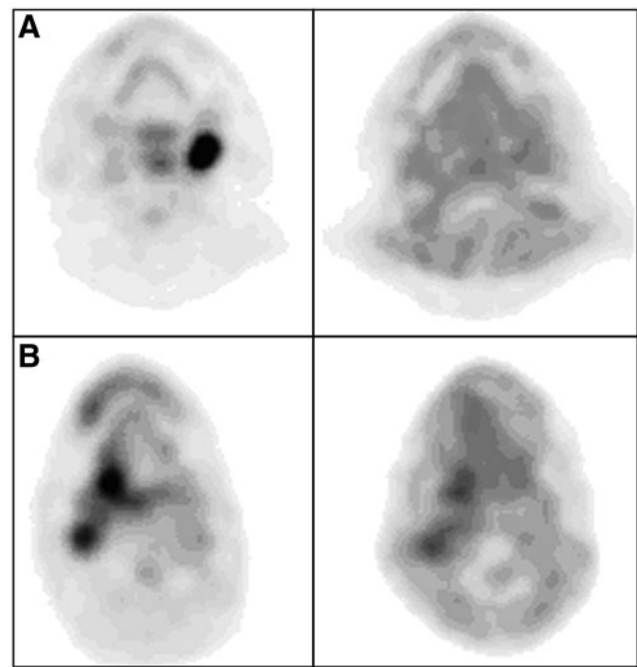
From left to right: transaxial ^{18}F -FDG PET; transaxial ^{18}F -FMISO PET of head and neck tumors. (A) normoxic ($\text{HP}_{2.5} = 13.0\%$; ^{18}F -FDG $\text{SUV}_{\text{mean}} = 14.80$; ^{18}F -FMISO $\text{T/M} = 1.31$). (B) hypoxic ($\text{HP}_{2.5} = 37.7\%$; ^{18}F -FDG $\text{SUV}_{\text{mean}} = 8.00$; ^{18}F -FMISO $\text{T/M} = 1.60$). Reprinted by permission from Gagel *et al.* (95). ^{18}F -FDG, ^{18}F -fluorodeoxyglucose; $\text{HP}_{2.5}$, hypoxic fraction below 2.5 mmHg; SUV, standard uptake value; T/M, tumor to muscle ratio.
